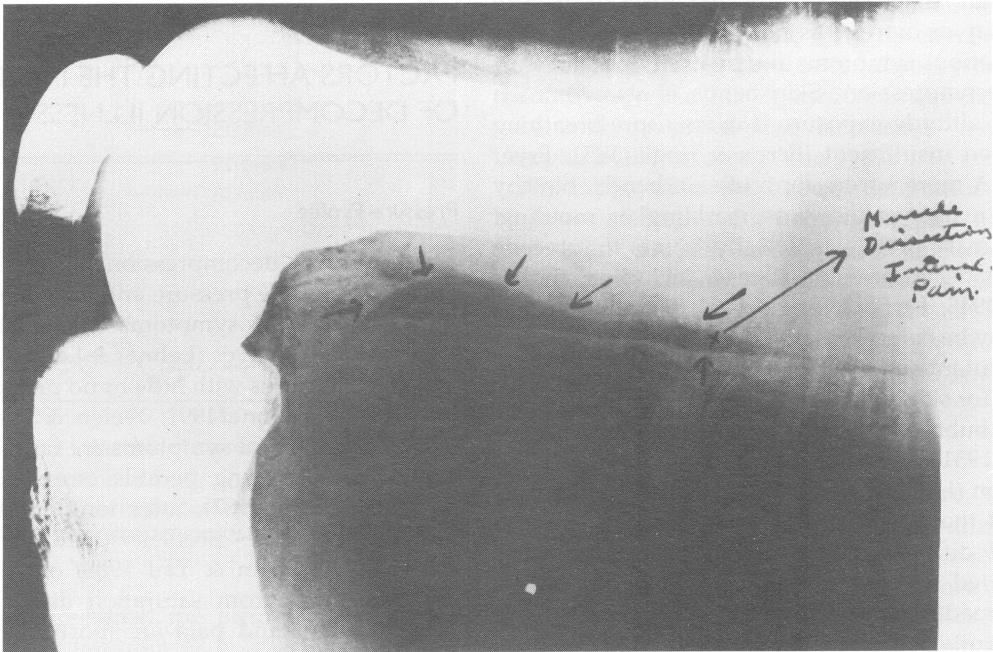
Radiograph of a bubble behind the knee of a subject at an unknown altitude c. 1945. US Army Air Force School of Aerospace Medicine, Randolph Field, Texas. (Courtesy of Dr A. A. Pilmanis)
